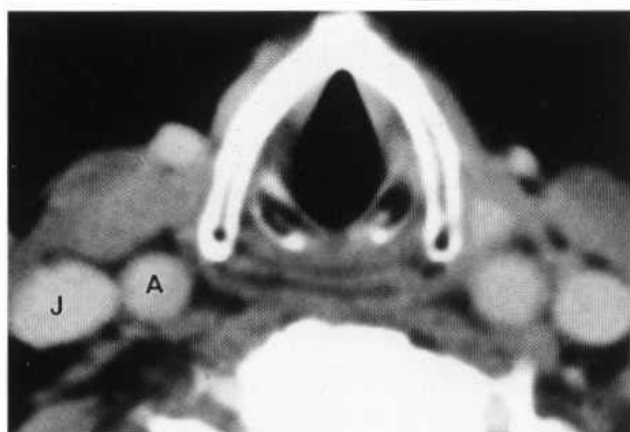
Axial CT of the normal larynx at the level of the true vocal cords. Note the diamond shape of the airway with the cords in abduction. Intravenous contrast has been given and so the common carotid artery (A) and internal jugular vein (J) are well shown.
